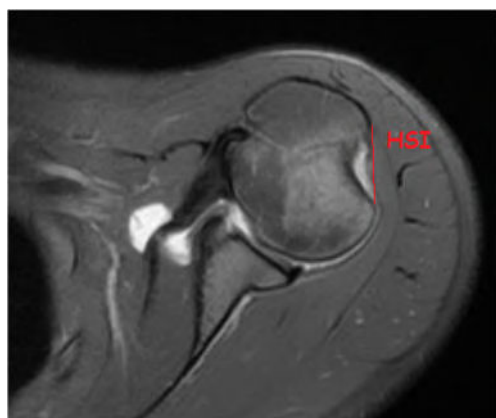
An axial cut on an MRI of the shoulder demonstrating the Hill-Sachs interval (HSI) from the medial most portion of the Hill-Sachs lesion to the insertion of the rotator cuff tendon
